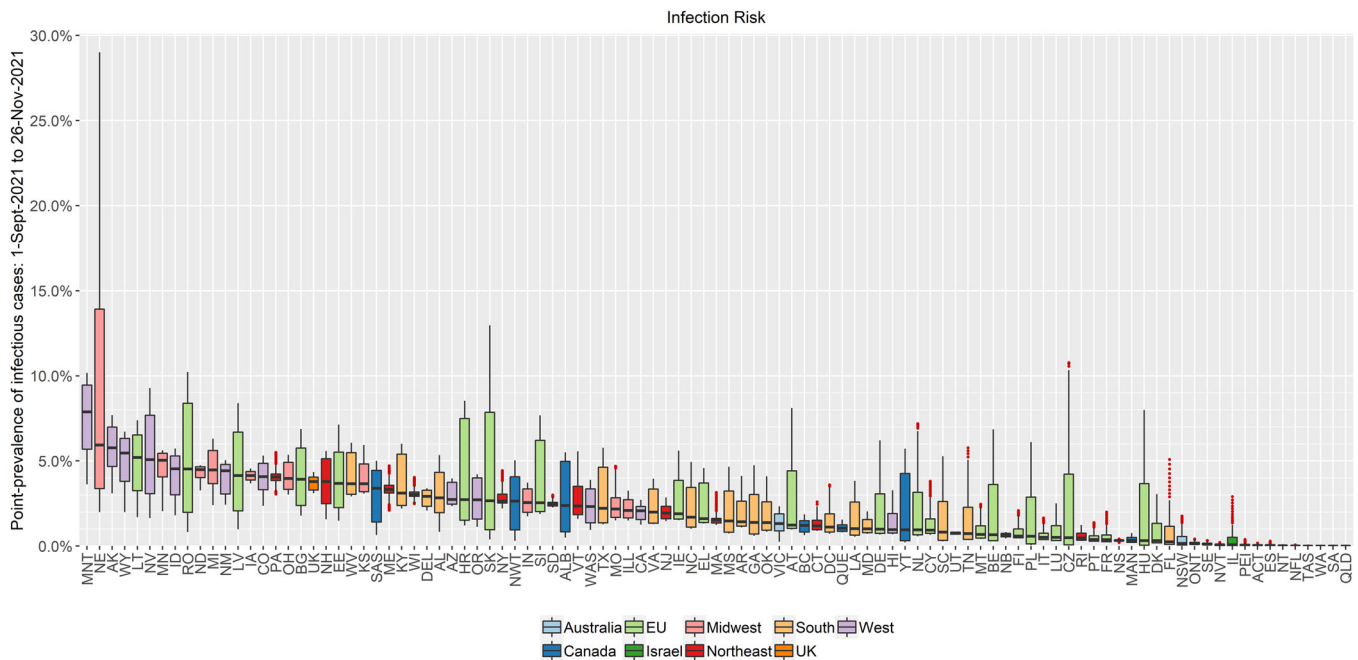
Daily infection risks from September 1 to November 26, 2021, by region and major jurisdiction. Major jurisdictions examined were EU member states, the UK, Israel, Canada, Australia, and the major US regions (Northeast, Midwest, South, West). The distribution of risks during this period are displayed using box-and-whisker plots. ACT, Australian Capital Territory; AK, Alaska; AL, Alabama; ALB, Alberta; AR, Arkansas; AT, Austria; AZ, Arizona; BC, British Columbia; BE, Belgium; BG, Bulgaria; CA, California; CO, Colorado; CT, Connecticut; CY, Cyprus; CZ, Czechia; DC, District of Columbia; DE, Germany; DEL, Delaware; DK, Denmark; EE, Estonia; EL, Greece; ES, Spain; FI, Finland; FL, Florida; FR, France; GA, Georgia; HI, Hawaii; HR, Croatia; HU, Hungary; IA, Iowa; ID, Idaho; IE, Ireland; IL, Israel; ILL, Illinois; IN, Indiana; IT, Italy; KS, Kansas; KY, Kentucky; LA, Louisiana; LV, Latvia; LT, Lithuania; LU, Luxembourg; MA, Massachusetts; MAN, Manitoba; MD, Maryland; ME, Maine; MI, Michigan; MO, Missouri; MN, Minnesota; MNT, Montana; MS, Mississippi; MT, Malta; NB, New Brunswick; NC, North Carolina; ND, North Dakota; NE, Nebraska; NFL, Newfoundland and Labrador; NH, New Hampshire; NJ, New Jersey; NL, Netherlands; NM, New Mexico; NS, Nova Scotia; NSW, New South Wales; NT, Northern Territory; NV, Nevada; NVT, Nunavut; NWT, Northwest Territories; NY, New York; OH, Ohio; OK, Oklahoma; ONT, Ontario; OR, Oregon; PA, Pennsylvania; PEI, Prince Edward Island; PL, Poland; PT, Portugal; QUE, Quebec; QLD, Queensland; RI, Rhode Island; RO, Romania; SA, South Australia; SAS, Saskatchewan; SC, South Carolina; SD, South Dakota; SE, Sweden; SI, Slovenia; SK, Slovakia; TN, Tennessee; TX, Texas; UK, United Kingdom; UT, Utah; VA, Virginia; VIC, Victoria; VT, Vermont; WA, Western Australia; WAS, Washington; WV, West Virginia; WI, Wisconsin; WY, Wyoming; YT, Yukon.
